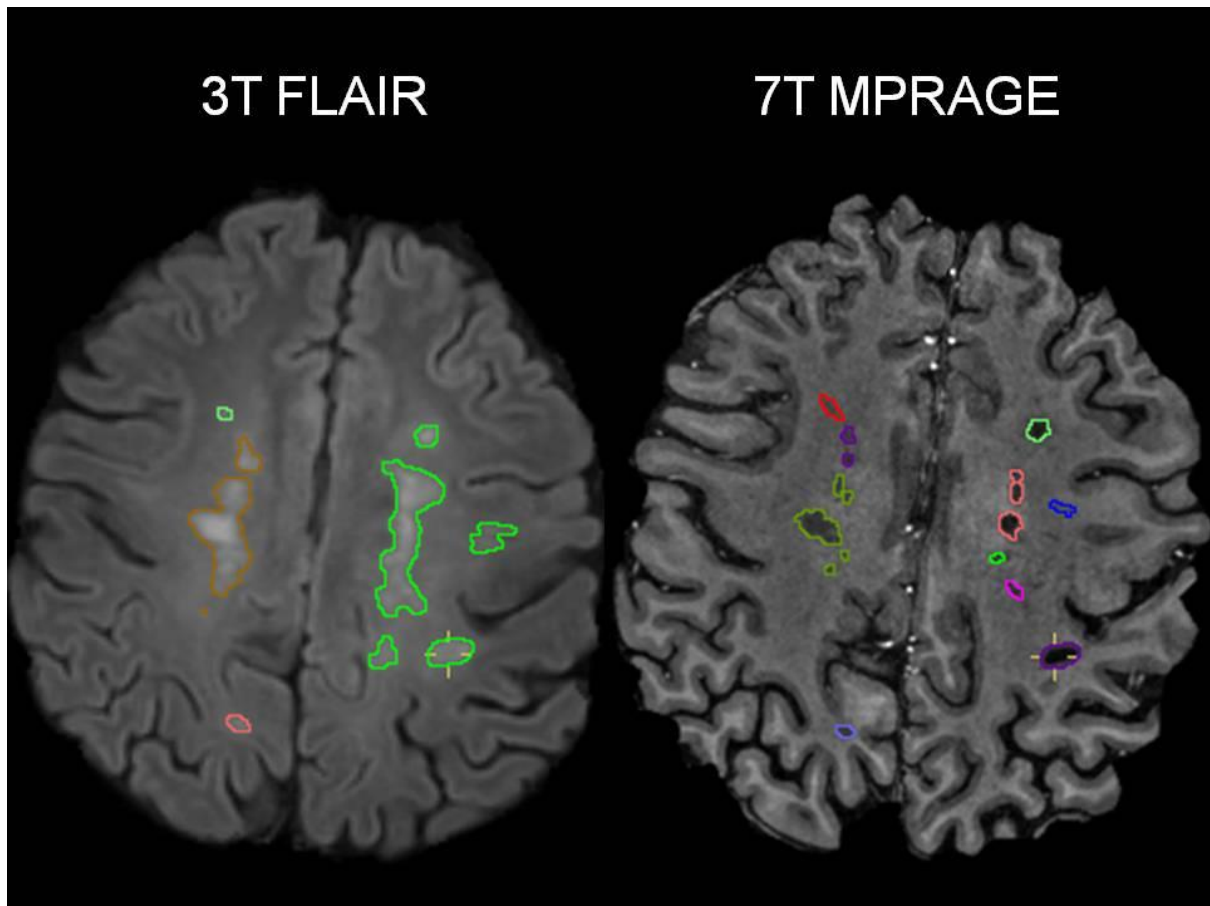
Examples of lesions prospectively identified on MPRAGE images and not on 3T FLAIR
